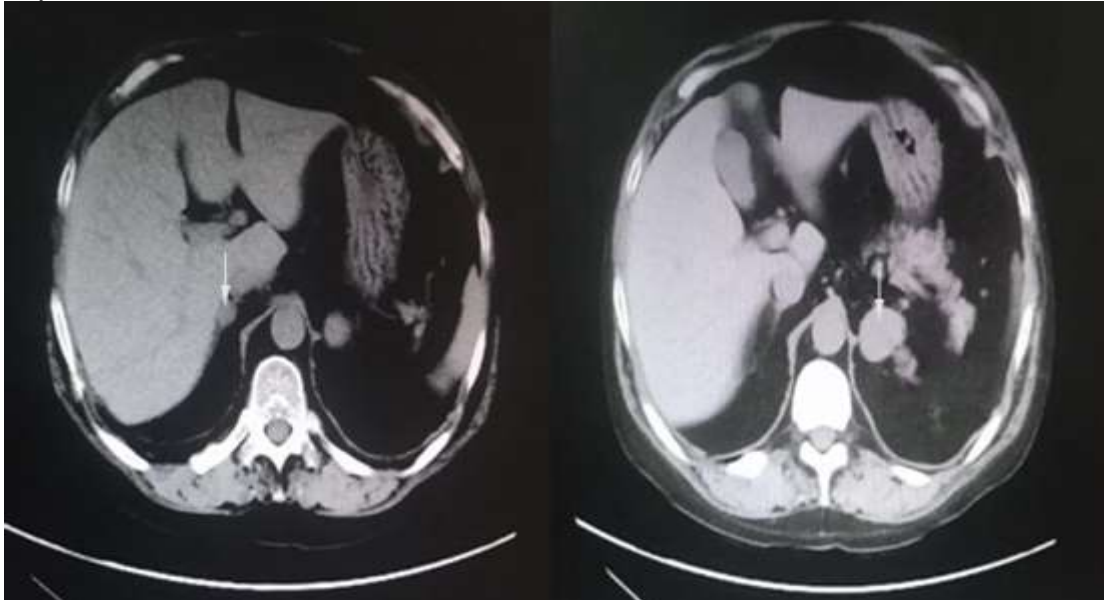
C- axial CT sections showing two adrenal masses, left 30 x 27 mm and right 15 x 13 mm.
